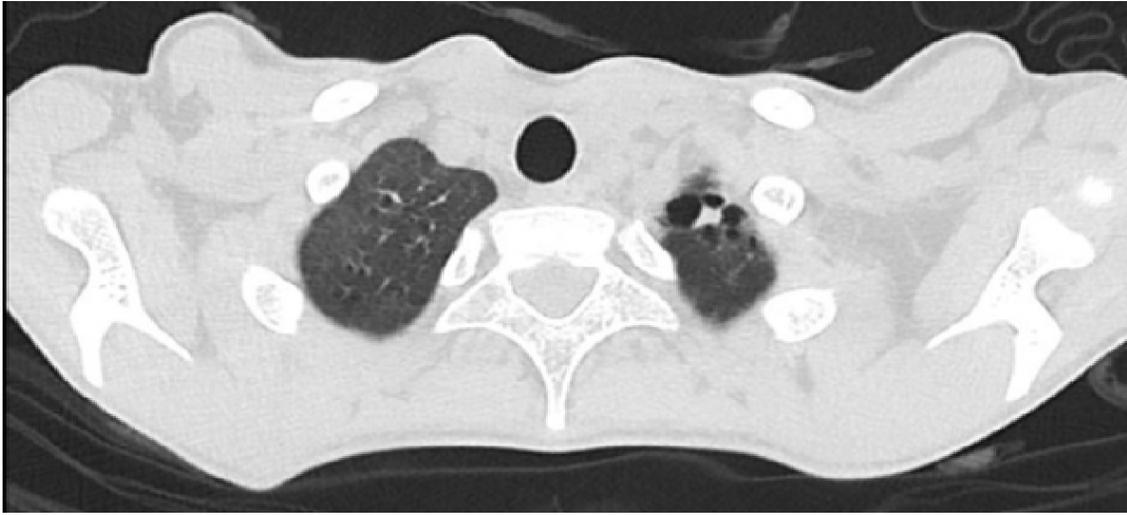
Chest CT showing left lung vertex micronodular and fibrobulous lesions.
